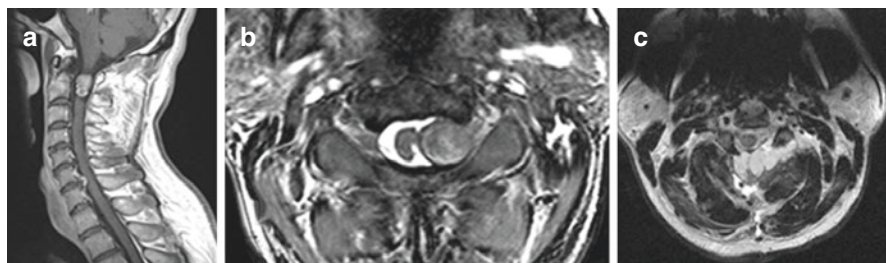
(a) Post-contrast sagittal T1-weighted MRI showing the enhancing tumor intradural, extramedullary tumor (schwannoma at C1–C2). (b) Axial T2-weighted MRI showing the left-sided tumor involving the C1–C2 intervertebral foramen and compressing the spinal cord. (c) Postoperative axial T2-weighted MRI showing the radical tumor resection. Note the fat graft overlying the dura dorsally and reinforcing dural closure
